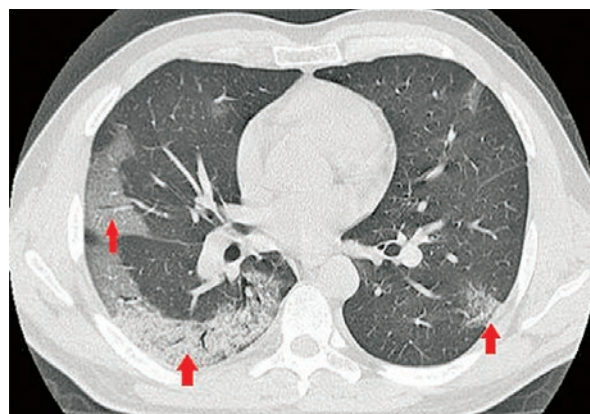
Chest CT in a patient with COVID-19 pneumonia on the third day of illness. Visible peripherally located ground glass opacifications (red arrows).
